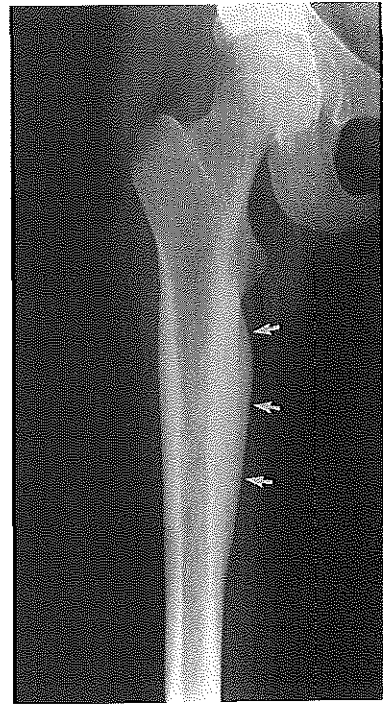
An additional radiograph of the right femur was made because of ipsilateral muscle wasting, revealing cortical sclerosis (arrows) that was caused by an osteoid osteoma.
